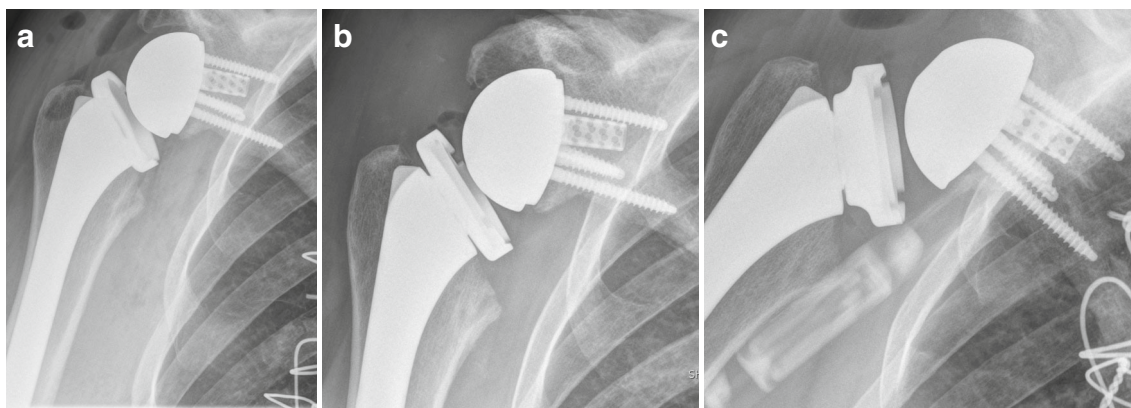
Case 2: a immediate postoperative radiographs with clear stepoff between glenosphere and baseplate; b stable incomplete glenosphere disengagement at two months; c postoperative radiographs after revision surgery (note glenosphere flush with baseplate)
